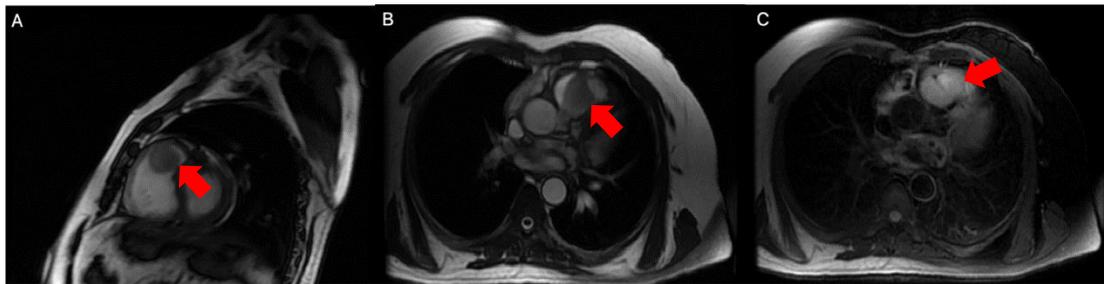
Cine steady state free precession MR images (A, C) showing a well-defined isointense mass located within the right ventricle outflow tract (Red arrow). The mass is hyperintense in T2-weighted image C.
